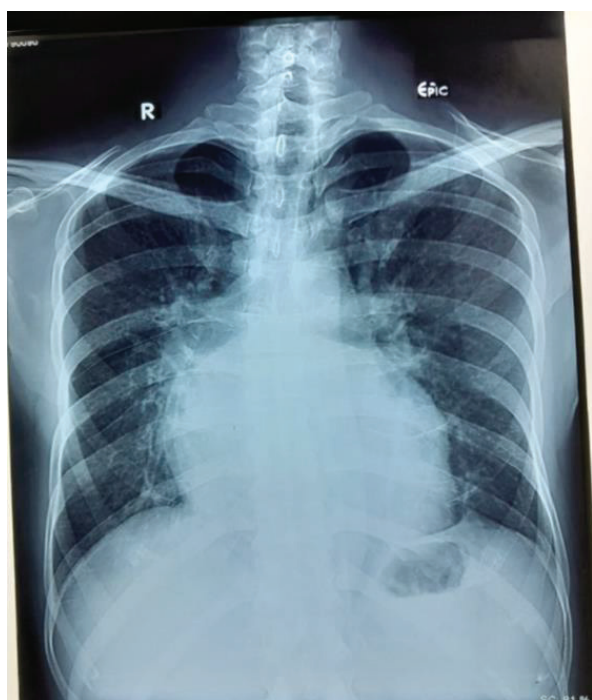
Chest x-ray showing “egg on a string” appearance, with enlargement of heart and narrowing of the upper mediastinum.
